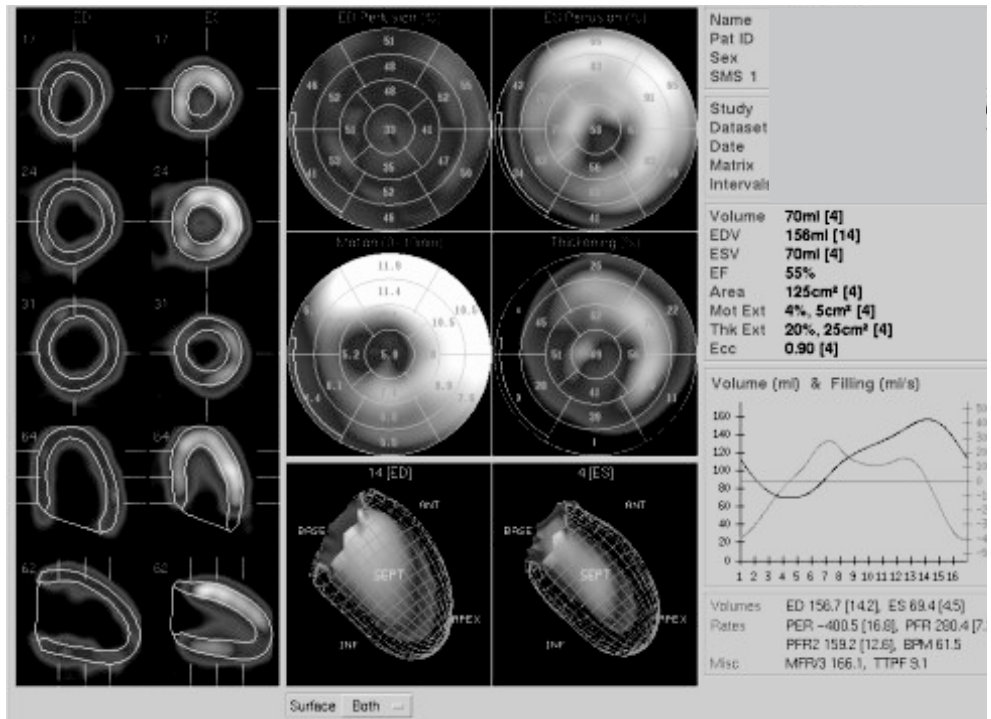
Polarmap display of gated SPECT. Perfusion of the end-diastolic and end-systolic phase is automatical quantified (upper row polarmaps). Wall motion (mm) and wall thickening (%) is also automatical quantified (middle row). The end-diastolic and end-systolic phase of the left ventricle (LV) is displayed in the lower row, showing endocard and epicard contours. End-diastolic, end-systolic and LV ejection fraction is calculated automatically and displayed on the right side. The short and long axes with the detection contours are displayed in the vertical row on the left side on the overview.
